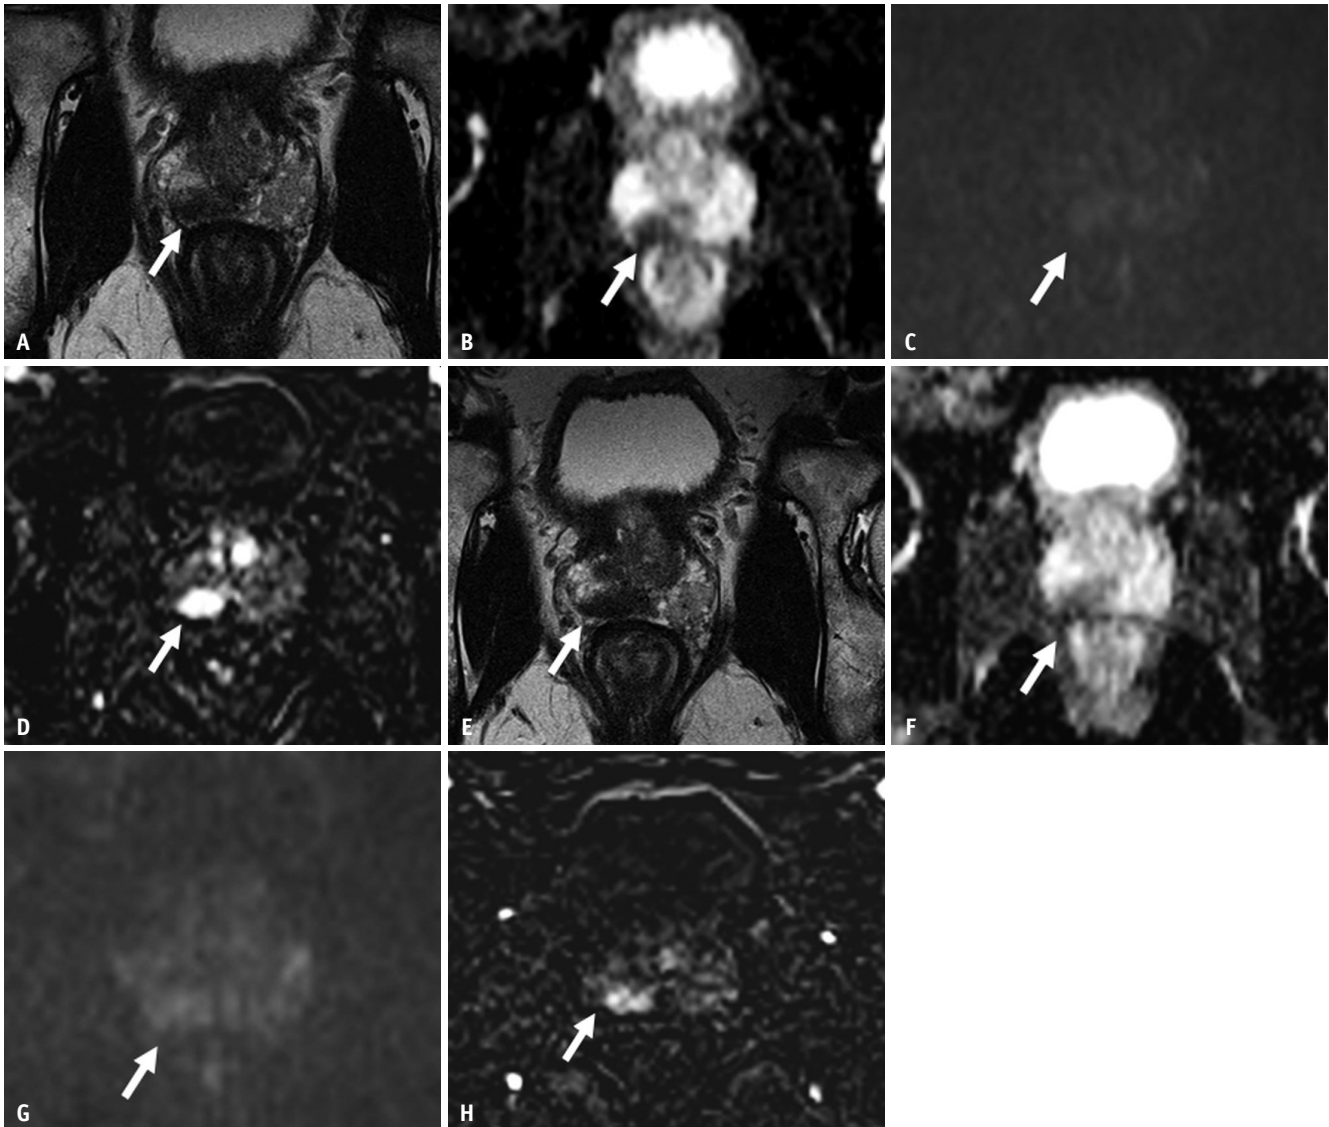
A 66-year-old male presented with an elevated serum PSA of 6.2 ng/mL. mpMRI was performed as a first-line investigation. A. T2-weighted imaging shows a circumscribed hypointense lesion in the transition zone at the right midgland (arrow). B. ADC map shows a moderate low signal (arrow). C. DWI shows moderate hyperintensity (arrow). This was graded as a PI-RADS 3 lesion. Both systematic and targeted biopsies were performed, which showed only a Gleason 3 + 3 cancer. The patient was deemed eligible for AS. Follow-up mpMRI was performed 1 year after baseline mpMRI before the confirmatory biopsy. Serum PSA had increased to 10.5 mg/mL. D. T2-weighted imaging shows a slight increase in the size of the hypointense lesion in the transition zone at the right midgland, now also appearing more obscured (arrow). E. ADC map shows a moderate low signal (arrow). F. However, the lesion appeared more hyperintense on DWI (arrow). The lesion was graded as PI-RADS 3, similar to baseline mpMRI. However, this was assigned a Prostate Cancer Radiological Estimation of Change in Sequential Evaluation score of 4 because of the increased lesion size, suggesting a high probability of radiologic progression. Both systematic and targeted biopsies were repeated. MRI-ultrasound fusion targeted biopsy showed a Gleason 3 + 4 cancer. The patient was taken off AS. ADC = apparent diffusion coefficient, AS = active surveillance, DWI = diffusion-weighted imaging, mpMRI = multiparametric MRI, PI-RADS = Prostate Imaging-Reporting and Data System, PSA = prostate-specific antigen
